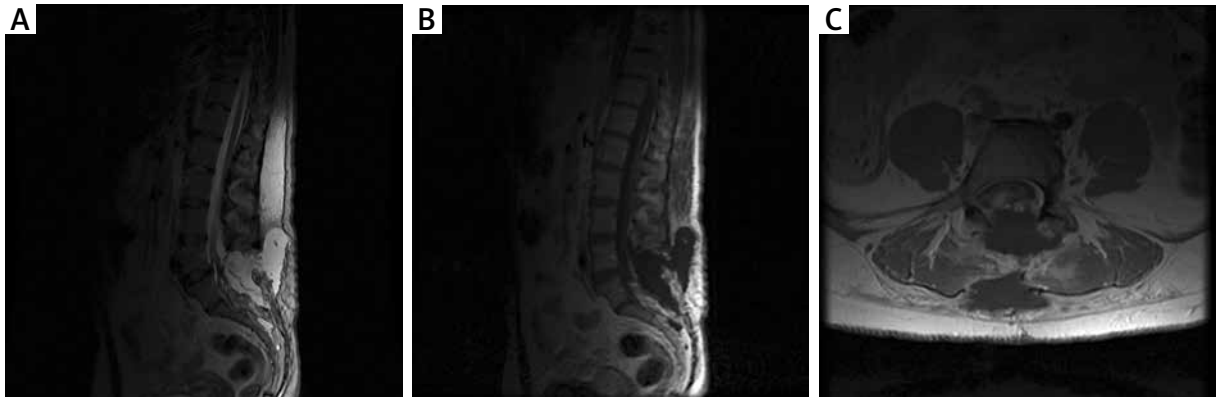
MRI examination in the early postoperative period in the first patient. A – T2-weighted postoperative study with visible fluid cyst. B – T1-weighted contrast-enhanced MR study with visible cyst and partially removed adipoma. C – Axial sections of T2-weighted contrast-enhanced MR study; fluid collection and degree of resection visible
